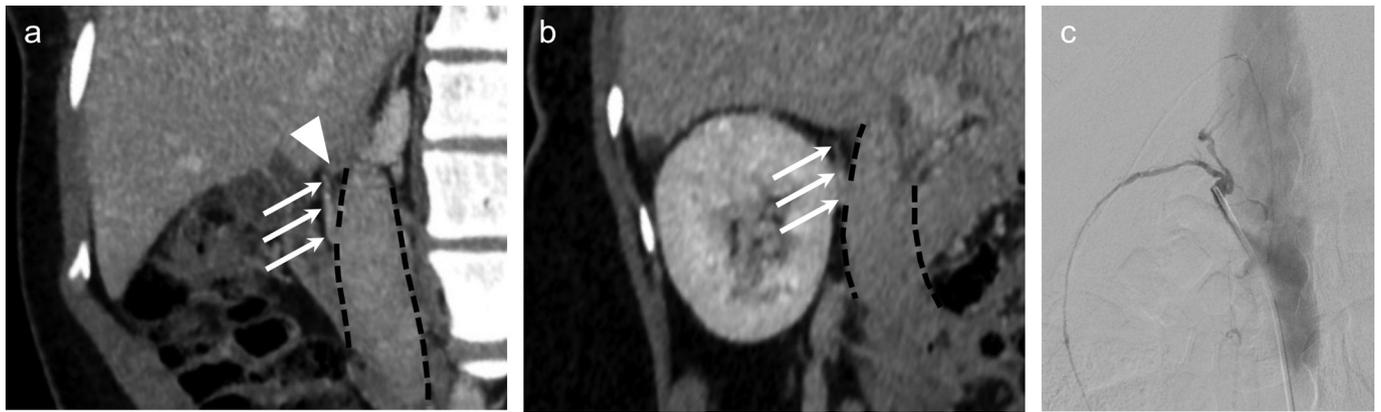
a-c. A 37-year-old female with hyperaldosteronism and initial AVS with difficulty in sampling the RAV; AVS results reveal bilateral adrenal suppression. CT venogram was subsequently performed prior to repeat AVS, which revealed a cranially oriented RAV. AVS using a multipurpose catheter for RAV sampling was successful, with lateralization to the right adrenal gland, consistent with right-sided aldosterone-producing adenoma. Panel (a) shows CT venogram using multiplanar reformatted images revealing a cranially oriented RAV (*white arrows*) draining the right adrenal gland, which is partially visualized on this image (*white arrowhead*). The IVC is outlined by the *black dotted line*. Orthogonal view (b) redemonstrating the cranially oriented RAV (*white arrows*) and further delineating the venous anatomy. Panel (c) shows successful RAV sampling (SI = 37.4) using the multipurpose catheter, which readily cannulated the cranially oriented RAV (vertical angle = 154°). Note the prominent inferior emissary vein, a reliable indicator for the RAV.
